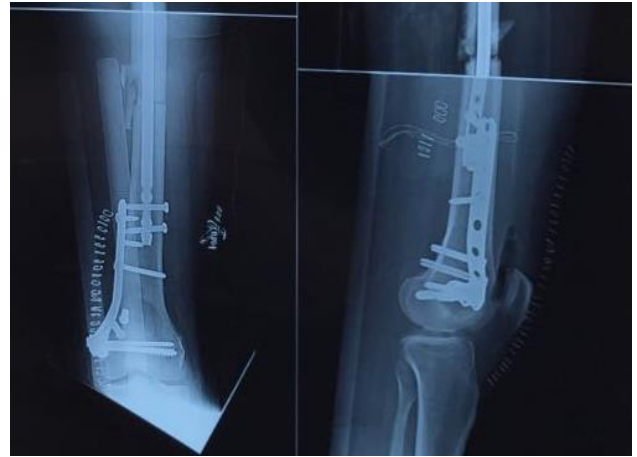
Post operative radiograph of shaft of femur and distal femur with A2 FN nail and proximal tibial ICP *in situ*, AP and lateral-view.
